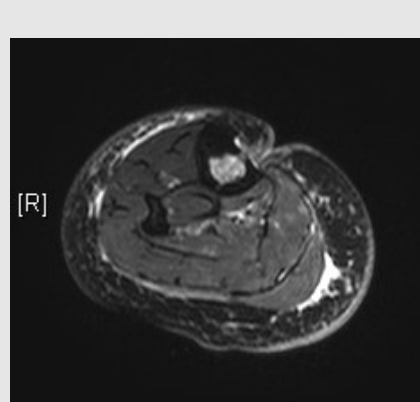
MRI scan confirmed CM stage III osteomyelitis.
